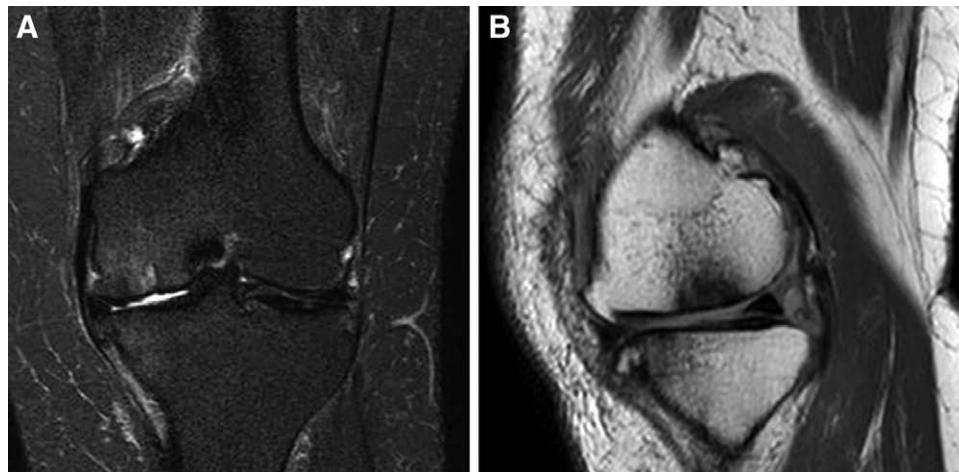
Preoperative MRI of a 50-year-old woman showing (A) a hyperintense signal on T2-weighted image on coronal view and (B) a hypointense signal on T1-weighted image at the medial femoral condyle on sagittal view.
